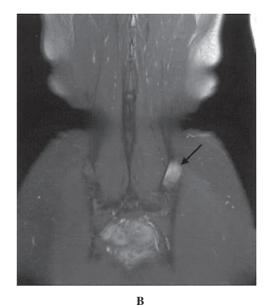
Coronal fat-suppression MRI images (in the order: A and B, in the dorsal direction). Arrows indicate bone metastases. A: The left side of the fifth lumbar spine and the left femoral head exhibit contrast enhancement suggestive of bone metastases. B: The left sacroiliac joint shows a contrast effect suggestive of a similar metastasis.
